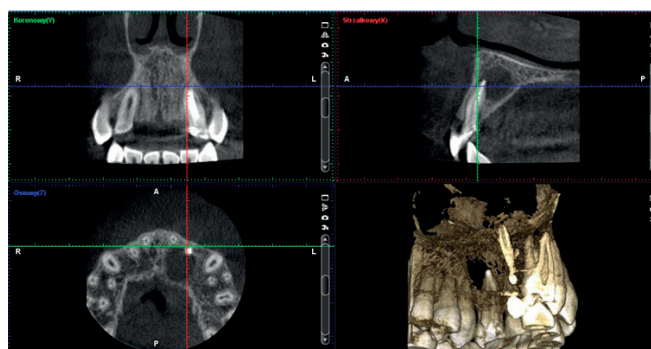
Cone beam computed tomography scans before root canal treatment in the endodontic clinic. Extensive destruction of the maxillary alveolar process bone near the apex of the root of tooth 22 is visible
